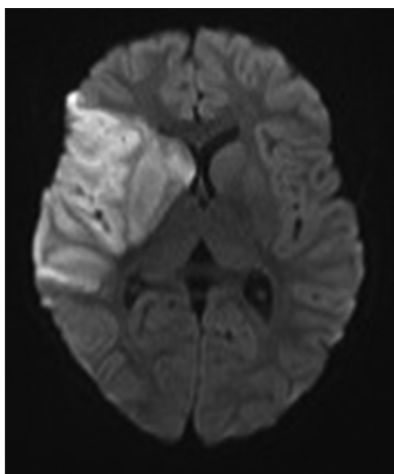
Magnetic resonance imaging (diffusion scan) showing right middle cerebral artery infarct
